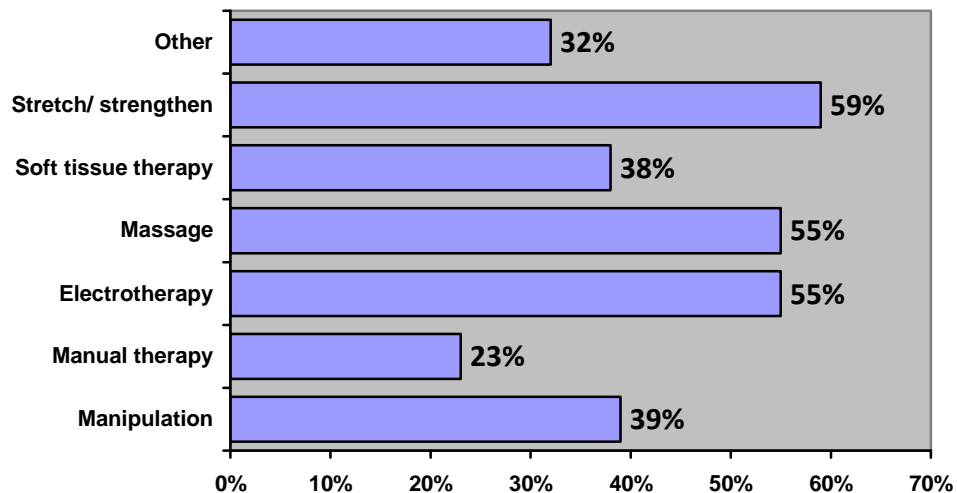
Management prior to x-rays
